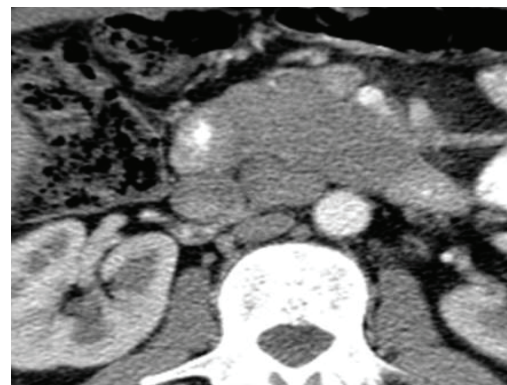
CT image- Lymphoma
